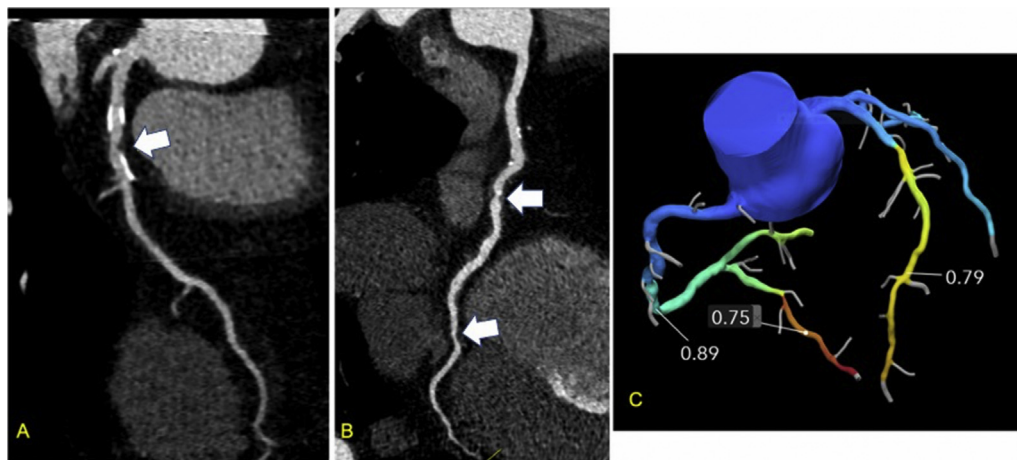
Cardiac CT-derived fraction flow reserve. Curved multiplanar reformatted images of the left anterior descending (A) and right coronary arteries (B) demonstrating multiple areas of moderate stenosis and diffuse plaque (arrows) that corresponded to decreased CT-FFR values (C). A CT-FFR value ≥ 0.80 is considered normal.
